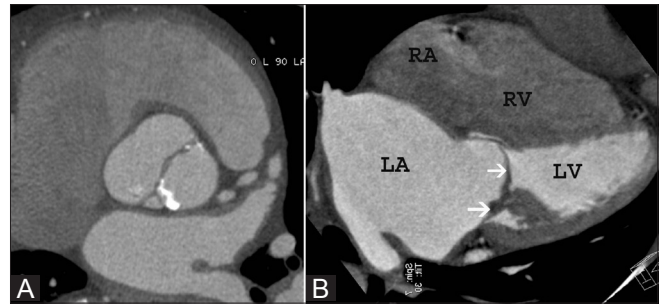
(A, B): Valvular lesions. Short-axis CT image (A) through the aortic valve shows a bicuspid valve, with calcification of the leaflet. Four-chamber reconstructed CT image (B) shows severe thickening of the mitral leaflets (arrows) in a patient with mitral stenosis with associated severe left atrial enlargement
